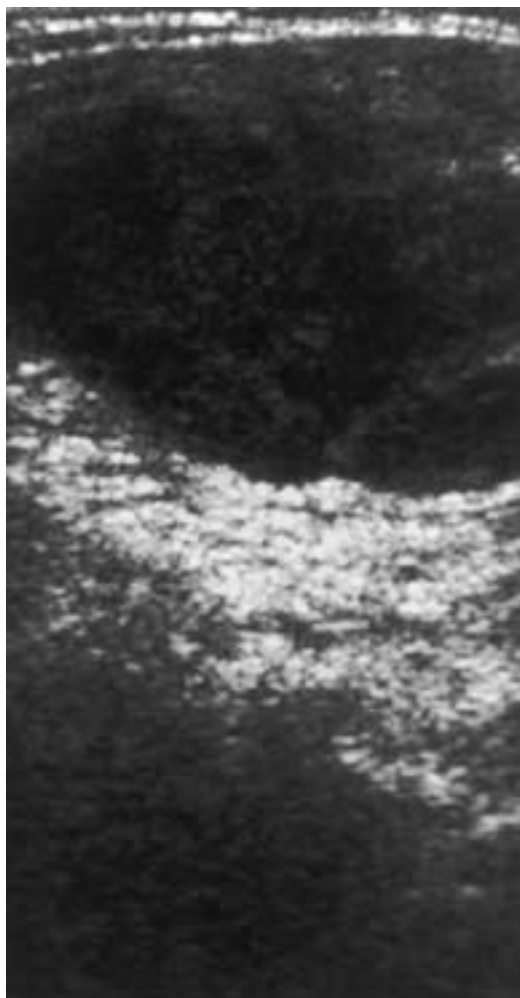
Anaplastic carcinoma. Sagittal sonographic image shows a large, hypoechoic mass in the thyroid gland.
